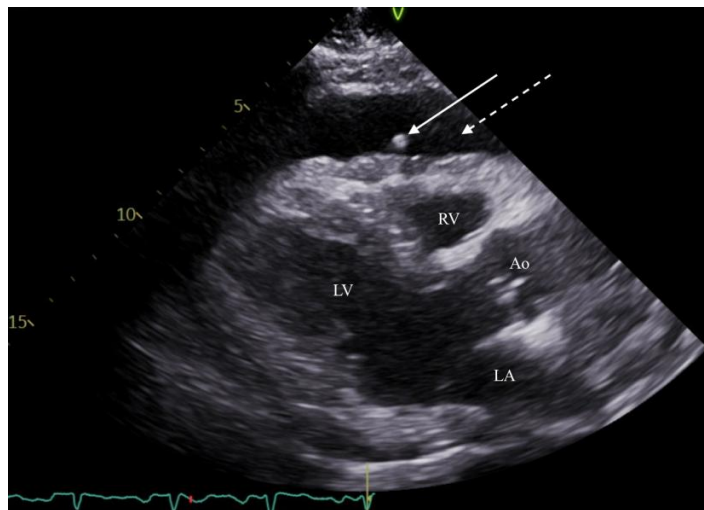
Formal transthoracic echocardiogram in the parasternal long axis following emergent pericardiocentesis with aspiration of air and placement of pericardial drain (solid arrow) with residual pericardial effusion (dashed arrow). Ao, aortic outflow tract; LA, left atrium; LV, left ventricle; RV, right ventricle.
